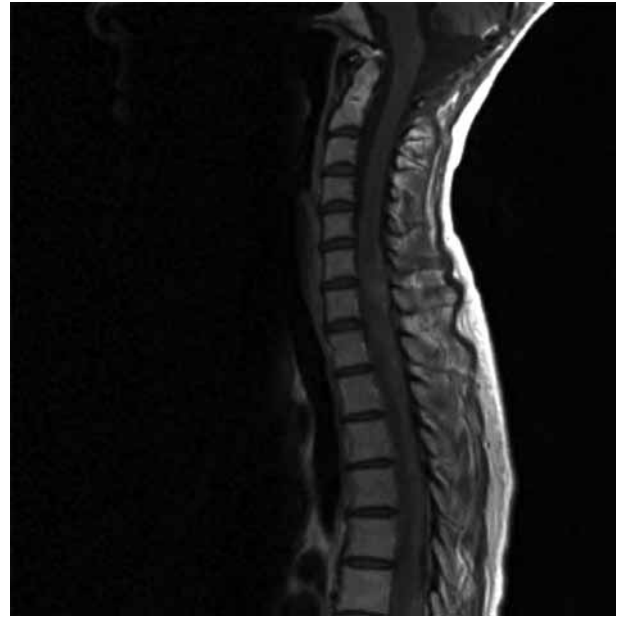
T1 weighted sagittal MRI after 4 months of treatment with temozolomide, showing no tumour growth and less tumour enhancement.
